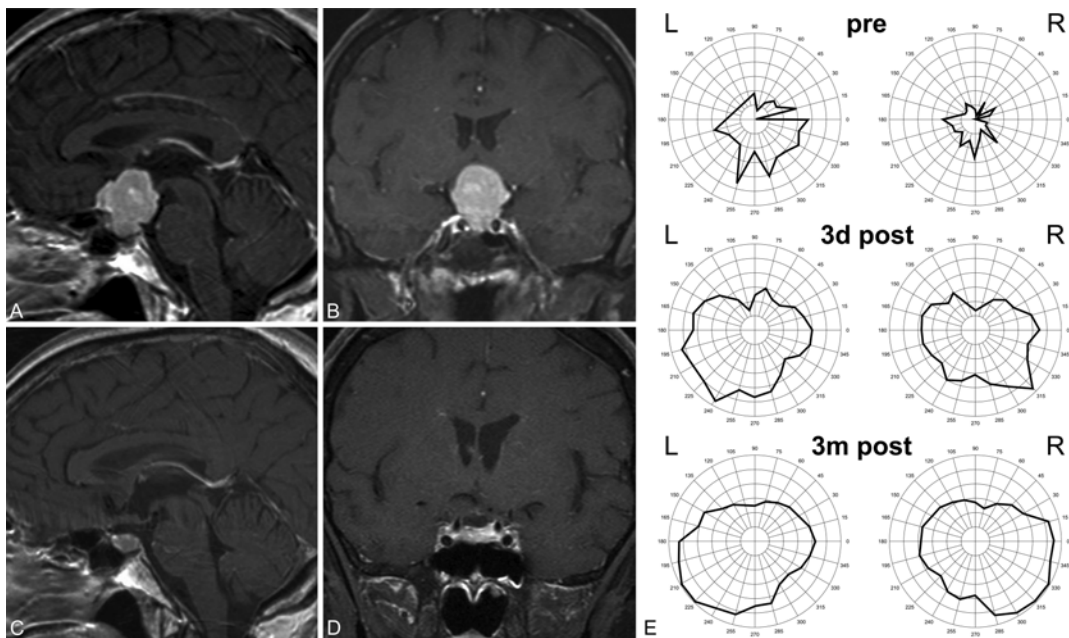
Case 7. Preoperative (A and B) and postoperative (C and D) sagittal (A and C) and coronal (B and D) contrast-enhanced MR images and results of visual field testing (E) obtained in a representative case in which TSM surgery was performed via a supraorbital craniotomy with an eyebrow skin incision. The improvement of the visual field can be seen from preoperative testing (pre) to testing performed 3 days after surgery (3d post) and 4 months after surgery (4m post).
